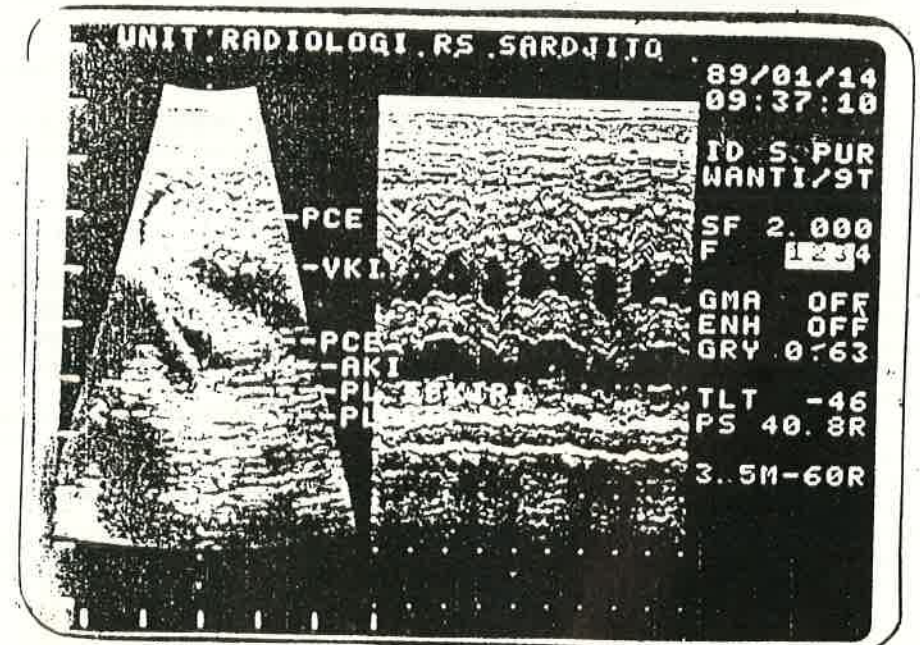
Echocardiogram taken immediately post pericardial tap, revealing considerable decrease of pericardial effusion
